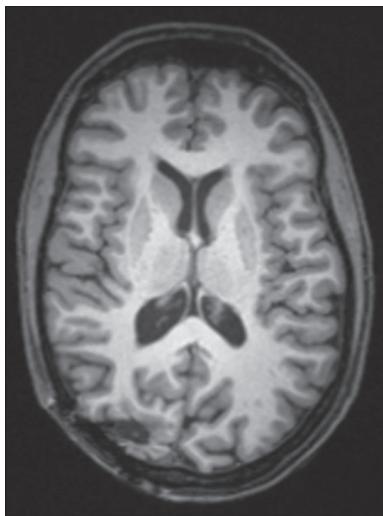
T1-weighted MRI demonstrating a right occipital scar two years after resection of an arterio-venous malformation.
